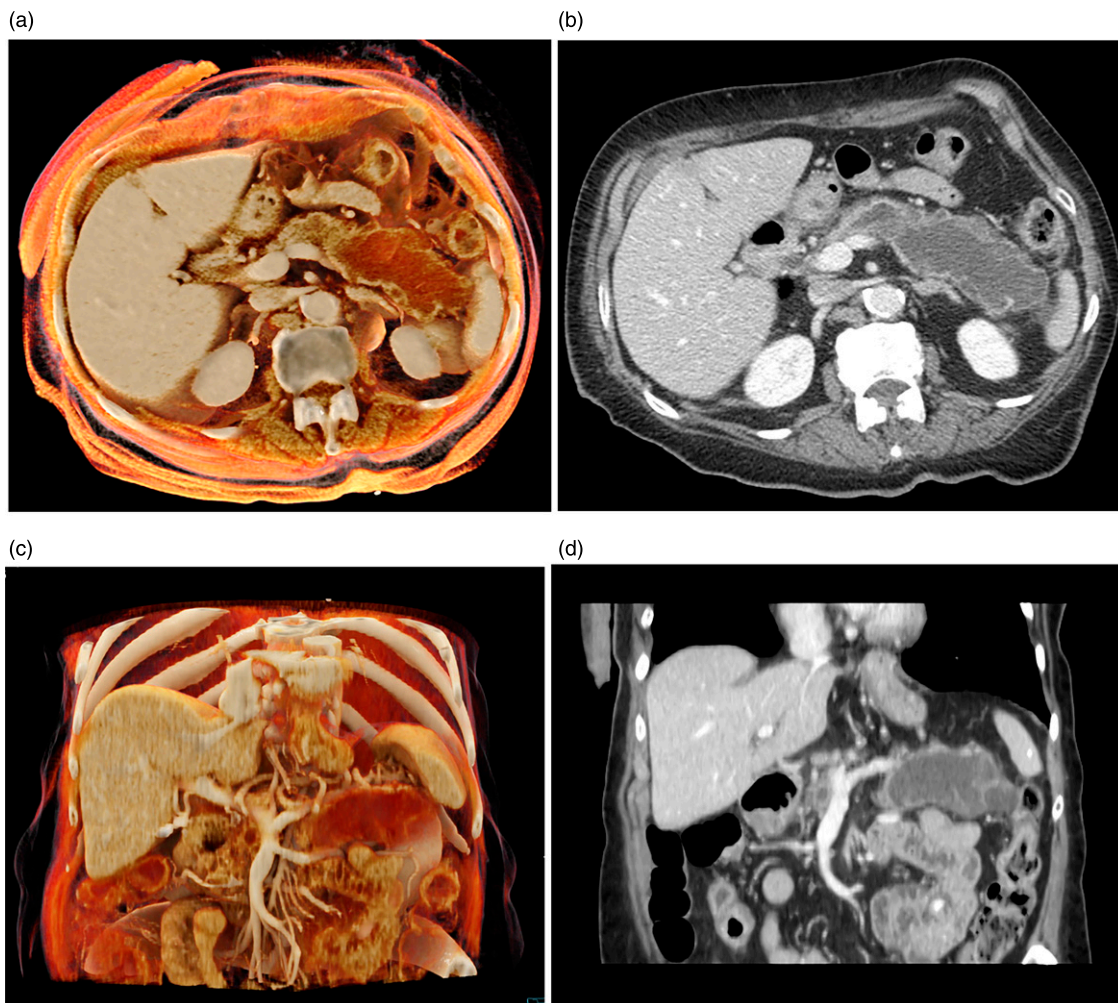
(a) Axial CT image (cinematic rendering) through the pancreatic tail mass. (Syngo Via, Siemens Healthcare, Erlangen, Germany) (b) Corresponding axial post contrast venous phase image through the pancreatic mass. (c) Coronal oblique cinematic rendered image through the pancreatic tail mass. Note the visualization of vasculature surrounding the pancreatic lesion. (d) Corresponding post contrast coronal reconstructed CT image. CT: Computed tomography.
